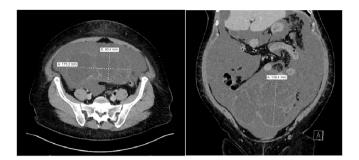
CT of the abdomen and pelvis demonstrating the pelvic mass and large ascites.
